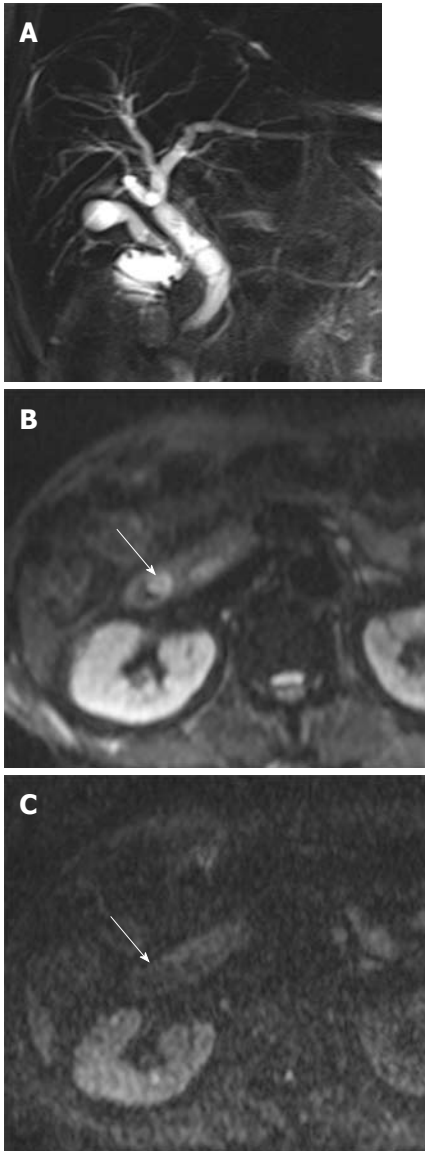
Papillitis due to a recently passed stone in a 75-year-old man. A: Coronal image from thick-slab single-shot MRCP shows mild bile duct dilatation; B: DWI at $b = 50 \text{ s/mm}^2$ shows a papilla with high signal intensity (arrow); C: On DWI at $b = 800 \text{ s/mm}^2$, the signal intensity of the papilla returns to the isosignal intensity (arrow). DWI: Diffusion-weighted magnetic resonance imaging; MRCP: Magnetic resonance cholangiopancreatography.
